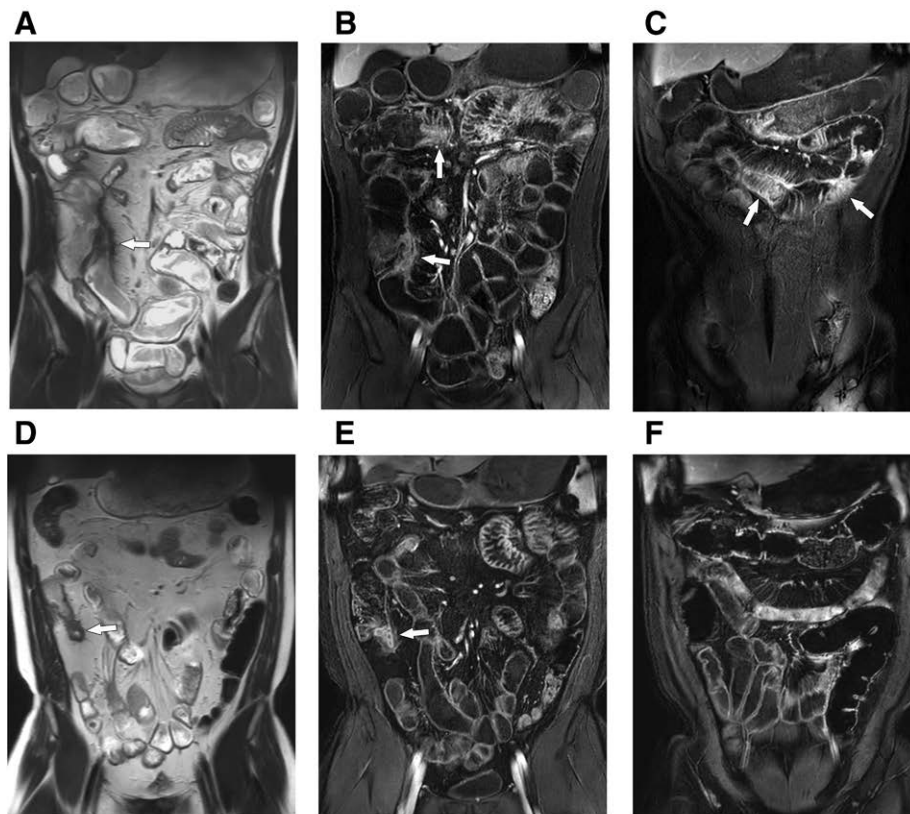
A 26-yr-old man with Crohn disease. Baseline coronal T2-weighted image and contrast-enhanced T1-weighted images (A–C) show active inflammation (arrows) in the terminal ileum, jejunum, ascending colon (not seen), and transverse colon. The global sMARIA was 12, and maximal segmental score was 5. Follow-up MRE images (D–F) show decreased and remaining wall thickening and edema in the terminal ileum (arrow) and much improved active inflammation in the other colonic segments. The global sMARIA was 3, and maximal segmental score was 2. MRE = magnetic resonance enterography, sMARIA = simplified magnetic resonance index of activity.
